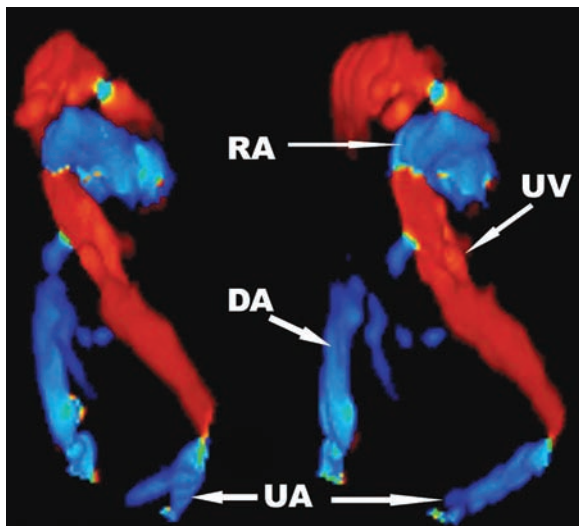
The same patient as in Figure 46.5, but the volume has been rendered in a 3D color Doppler again without the gray-scale information. The information provided from 3D color Doppler is similar to the one provided by 3D power Doppler, but in color Doppler we have additional information regarding the direction of flow. RA, right atrium; DA, ductus venosus; UV, umbilical vein; UA, umbilical arteries.
